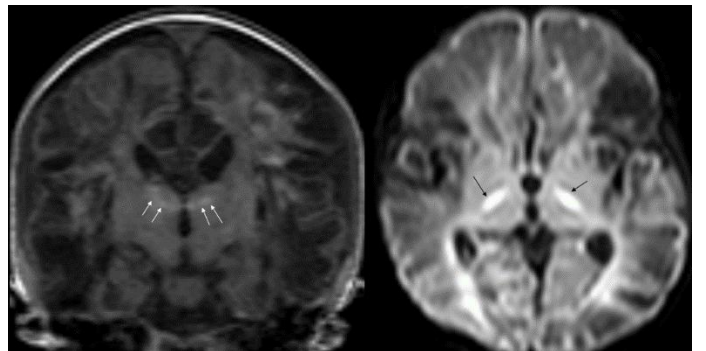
Coronal T1 and Axial DWI images showing T1 high signal intensity and diffusion restriction involving posterior limb of internal capsule
